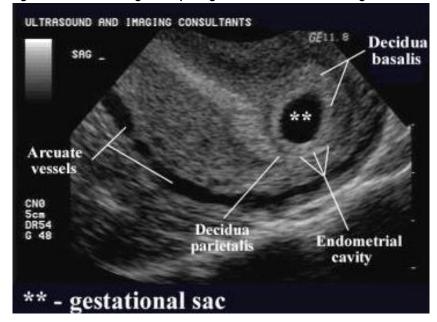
An ultrasonogram depicting the double decidual sac sign
